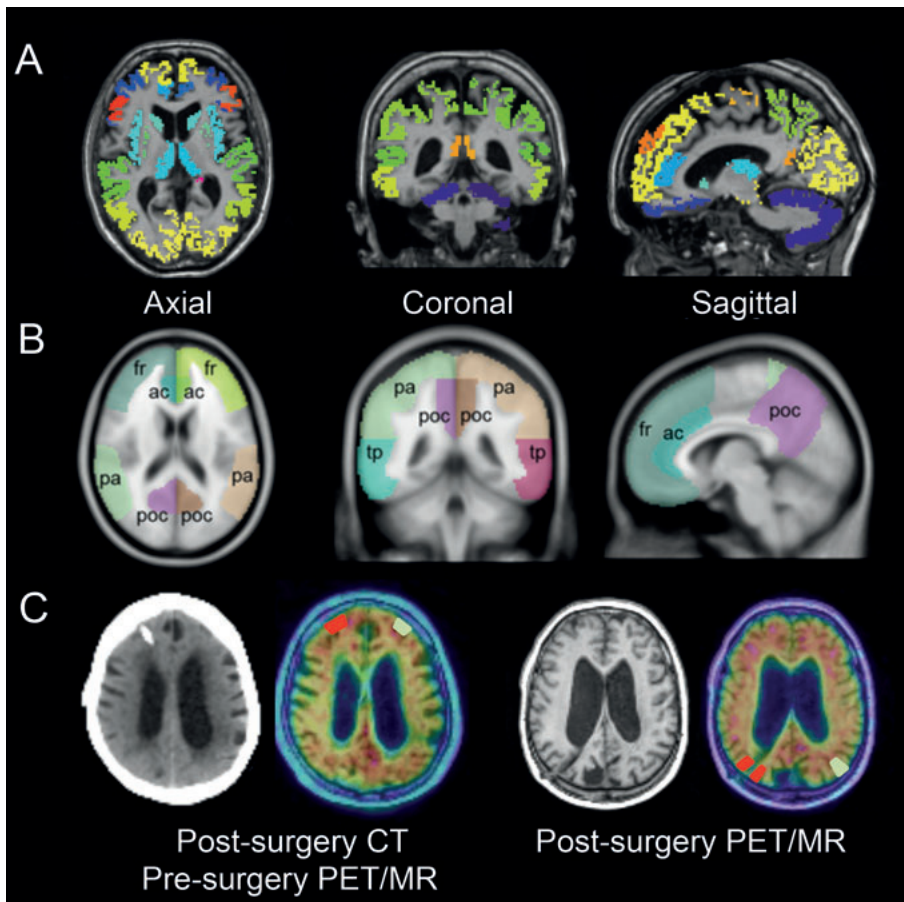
A) MRI segmented grey matter VOIs from PVELab. B) MNI template space VOIs, fr = frontal cortex, ac = anterior cingulate, pa = parietal cortex, poc = posterior cingulate and precuneus, tp = lateral temporal cortex. C) Left: Post-surgery CT and pre-surgery PET/MRI overlay with biopsy VOIs as outlined in patients having [^{18}F]flutemetamol scan performed before the shunt placement procedure. Right: Post-surgery MRI and PET/MRI overlay with biopsy VOIs as outlined in patients having [^{18}F]flutemetamol scan performed after the shunt placement procedure.
